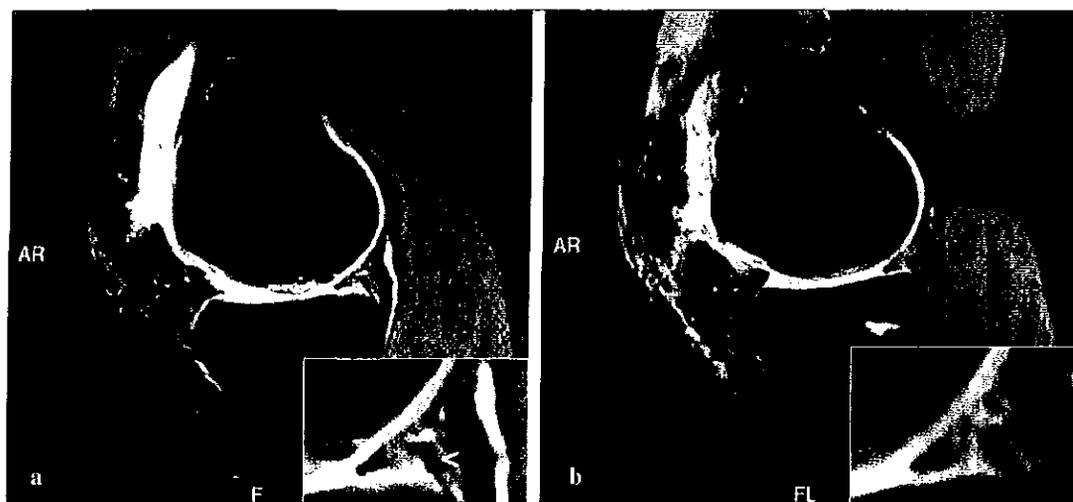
T2-weighted FSE fat-suppressed MR images. a Six months postoperatively, the implant shows a non-homogeneous signal and appears in continuity with the parameniscus. *Inset*, close-up of the implant. <, Non-absorbable suture. b Control at one year: the signal appears more homogeneous
